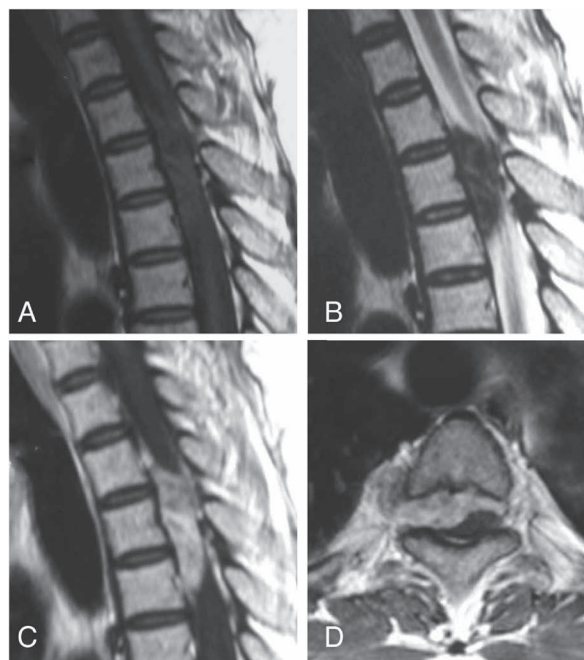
MR images : A) T1-weighted sagittal image, B) T2-weighted sagittal image, C) T1-weighted sagittal image after administration of Gd-DTPA. D) T1-weighted axial image at the T3/4 level. The tumor is hypointense both on T1- and T2-weighted images and homogeneously enhances after intravenous injection of Gd-DTPA. On the axial image, the tumor extends into the right paravertebral space through the neural foramen and presents as a dumbbell-type lesion.
